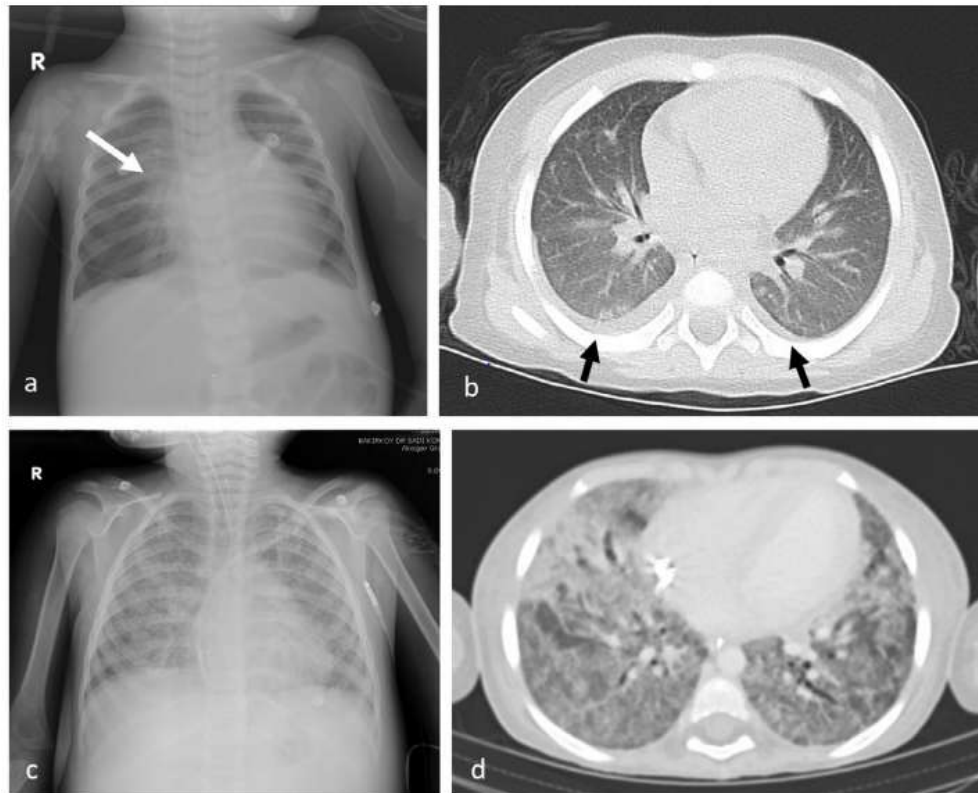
A chest X-ray of a 2-year-old boy reveals perihilar opacity and peribronchial thickening, indicated by a white arrow (a). In another case, a thoracic CT scan of a 23-month-old girl displays bilateral pleural effusion, marked by black arrows (b). Additionally, imaging of a 4-year-old girl shows bilateral diffuse opacities, ground-glass densities, and consolidation on both chest X-ray and thoracic CT (c, d) [66].
